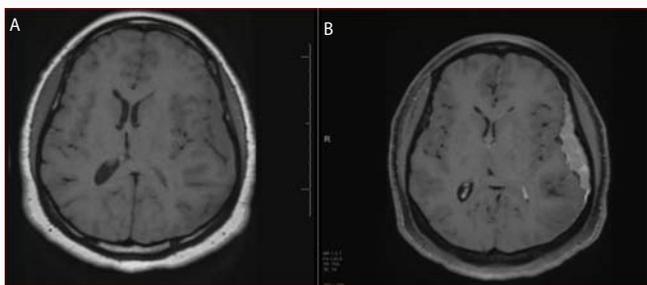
(A) 3T Brain MRI Axial T1 WI without Gadolinium: Isointense left convexity extra axial lesion (Arrow). (B) 3T Brain MRI Axial T1 WI post Gadolinium: Homogenous avidly enhancing left convexity extra axial lesion.
